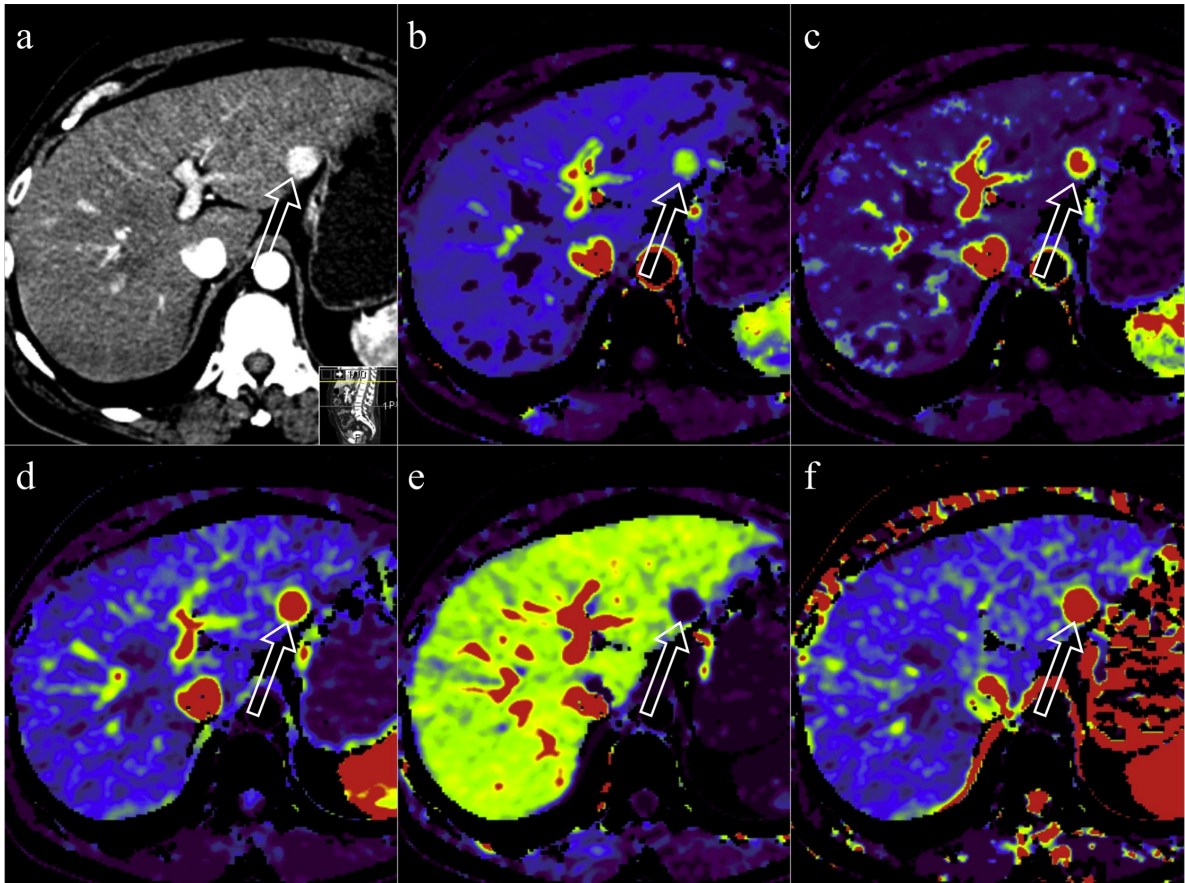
Perfusion CT of a patient with liver cirrhosis and a hepatocellular carcinoma (arrow) in the left lateral liver segment. Image (a) represents a time-resolved maximum intensity projection and (b–f) are colour-coded maps of the following perfusion parameters: blood flow (b), blood volume (c), arterial liver perfusion (d), portal-venous liver perfusion (e) and hepatic perfusion index (f). With permission to reprint from Elsevier B.V., Kartalis et al.*³¹
